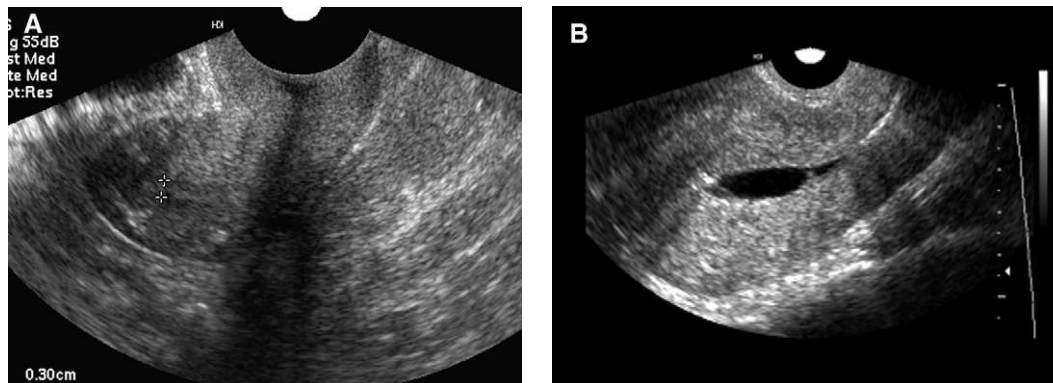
(A) Mid-sagittal ultrasound image demonstrates a thin atrophic endometrium. (B) Mid-sagittal image obtained during a saline infusion sonohysterogram demonstrates virtually no endometrium consistent with atrophy.
